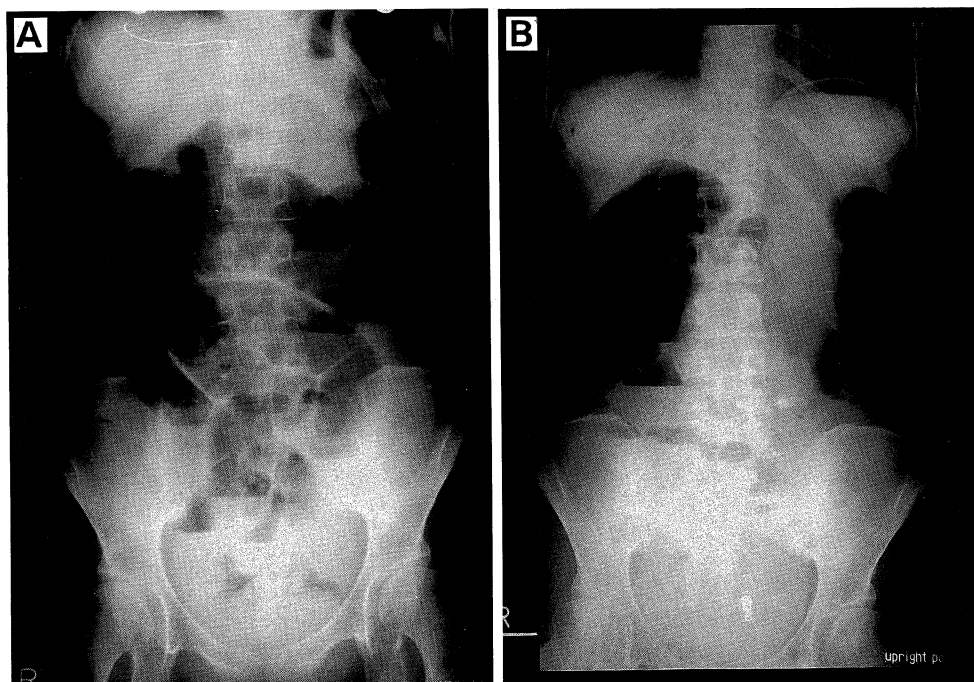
Case 1. A: A roentgenogram (before octreotide treatment) showing marked intestinal distension. B: Intestinal distension was dramatically improved by octreotide. A roentgenogram was taken on day 10 of treatment.
